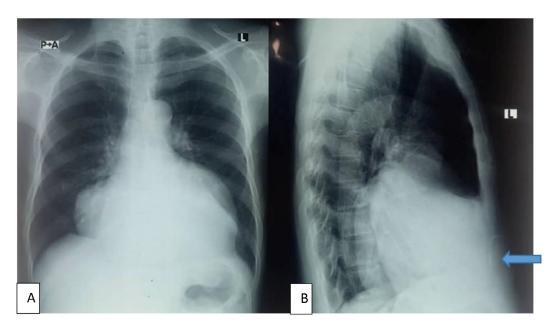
(A and B) Postpercutaneous drainage chest radiograph showing (PA) and lateral chest radiograph showing minimal change in size of pericardial cyst. Drainage tube seen in situ (on lateral radiograph.
